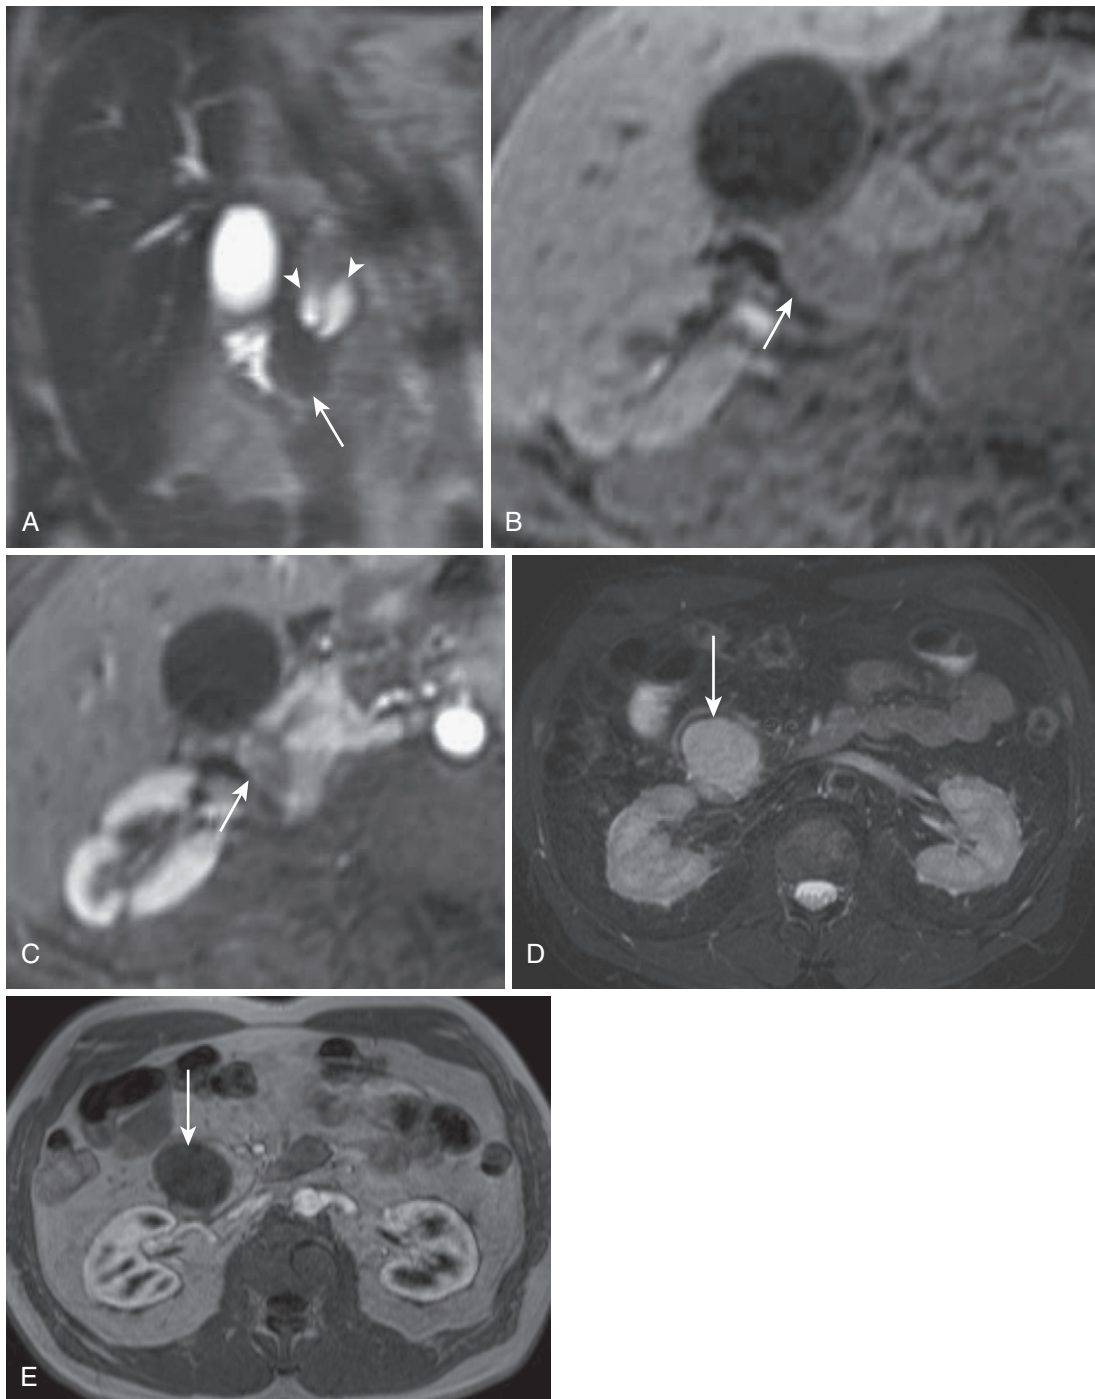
Nonfunctioning islet cell tumors. A, The T2-weighted image shows a small polypoid lesion in the ampullary region (*arrow*) obstructing the CBD and pancreatic duct (*arrowheads*). Precontrast (B) and postcontrast (C) images demonstrate corresponding lesional T1 hypointensity and hypovascularity (*arrow*) in this small nonfunctional islet cell tumor presenting with biliary obstruction. A large nonfunctional islet cell tumor in the pancreatic head (*arrow*) in a different patient demonstrates marked hyperintensity on the T2-weighted image (D) and absent enhancement on the postcontrast image (E).
